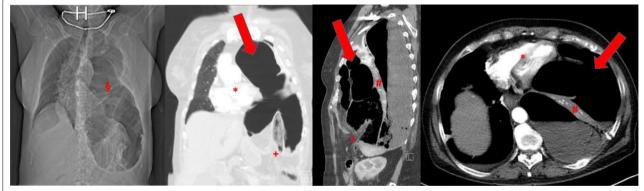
CT overview with suspected pneumothorax on the left (§). Left-sided tension enterothorax (red arrow) with displacement of the mediastinum to the right and compression of the heart (*). Total atelectasis of the left lung (#). Atypical diaphragmatic defect (+)
